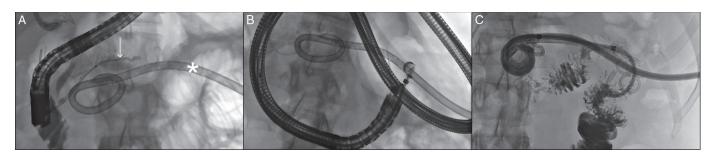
Endoscopic ultrasound-guided management of a PCF arising after percutaneous drainage of pancreatic necrosis in case 2. (A) Endoscopic retrograde cholangopancreaticography demonstrates a complete obstruction of pancreatic duct (arrows) by the percutaineous drain (asterisk) (B) Endoscopic ultrasound-guided transmural puncture of the percutaneous drain from the fourth portion of the duodenum. (C) Multiple internal double pigtail plastic stents were placed to drain the fistula tract and pancreas into the duodenum.
